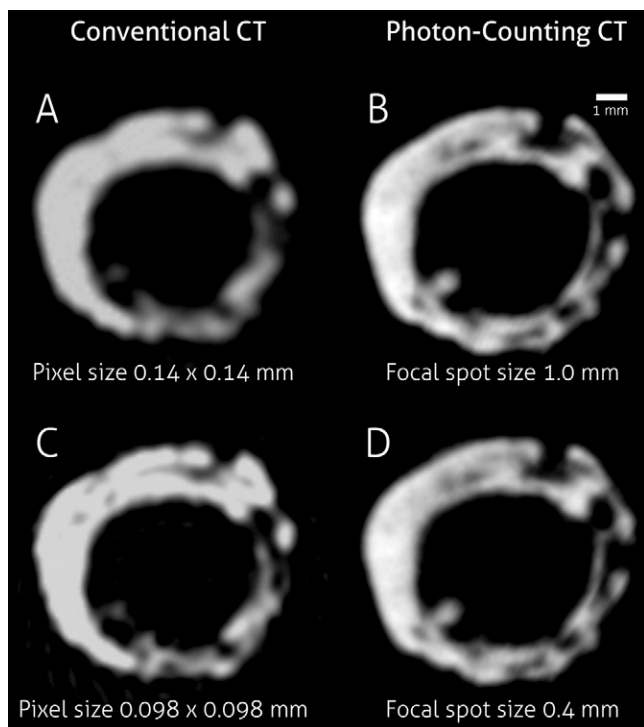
Images of ex vivo carotid artery cast in paraffin obtained with conventional clinical CT with 80 kVp and, *A*, normal resolution ($0.14 \times 0.14 \text{ mm}^2$ pixels) and, *C*, high spatial resolution ($0.098 \times 0.098 \text{ mm}^2$ pixels). For comparison, images were also acquired with a photon-counting silicon-strip detector module in a tabletop imaging setup, at 80 kVp, by using, *B*, normal focal spot size (focal spot size, $1.0 \times 1.0 \text{ mm}^2$) and, *D*, small focal spot size (focal spot size, $0.4 \times 0.4 \text{ mm}^2$). Image processing has been applied to remove ring artifacts. Note the high spatial resolution of the photon-counting CT images. (Image courtesy of Mats Danielsson, PhD, KTH Royal Institute of Technology, Stockholm, Sweden.)
